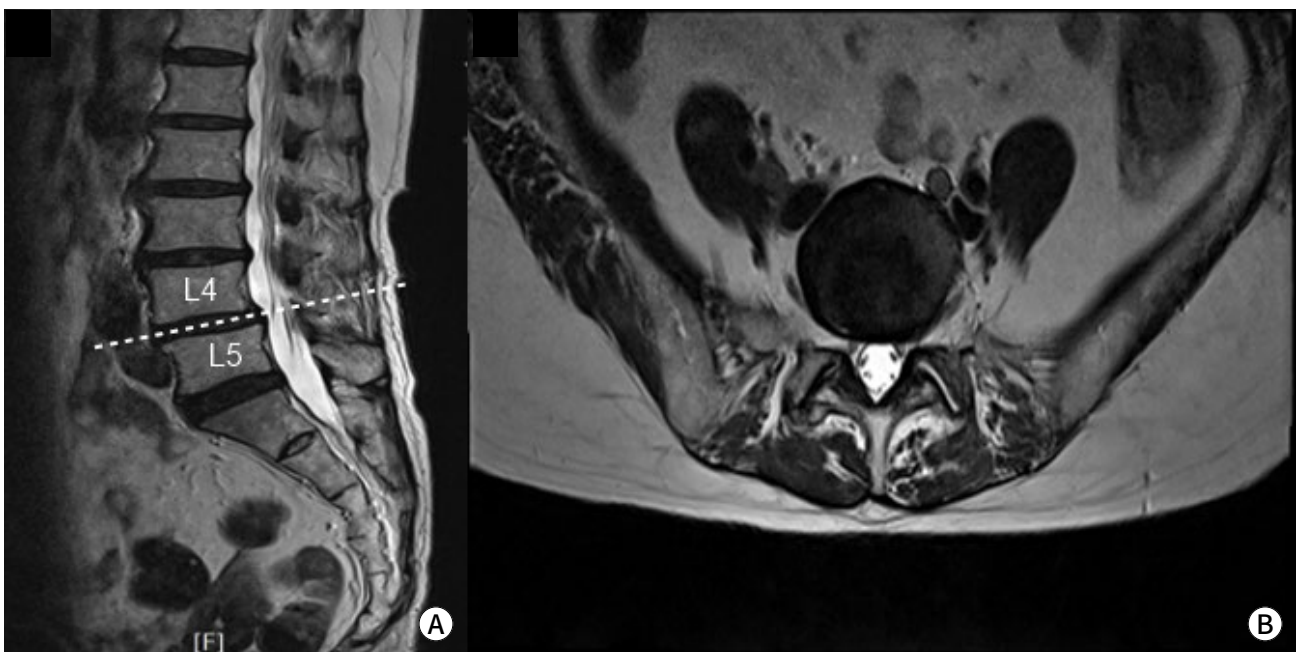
Lumbar MRI. (A) Sagittal view, (B) axial view.
